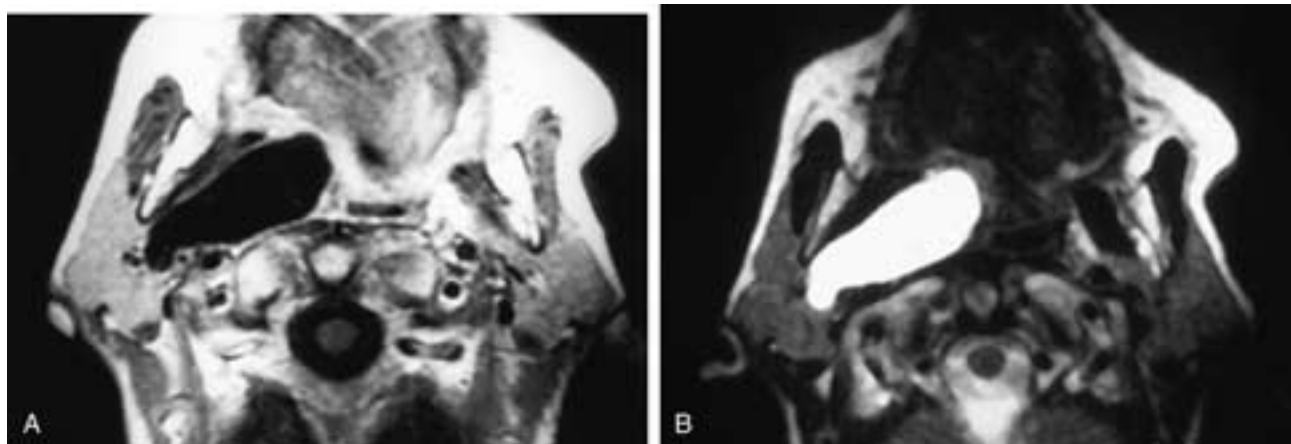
Axial T1-weighted (A) and T2-weighted (B) MR images show a large cyst extending from the right parotid gland into the right parapharyngeal space. The entire deep portion of the gland is occupied by the cyst. This patient had a second branchial (pouch) cyst.
